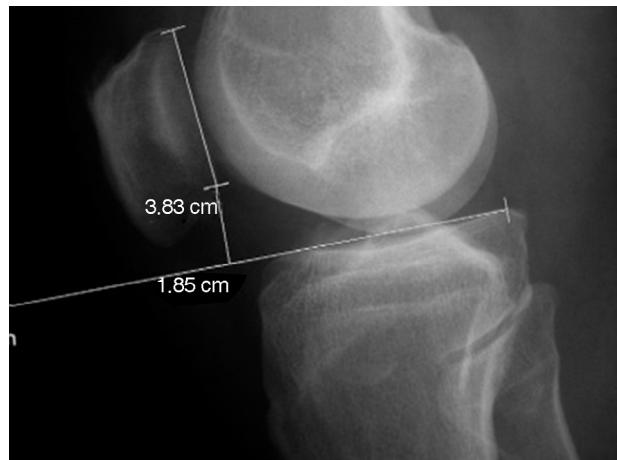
Lateral-view radiograph of the knee. Blackburne-Peel calculation.
